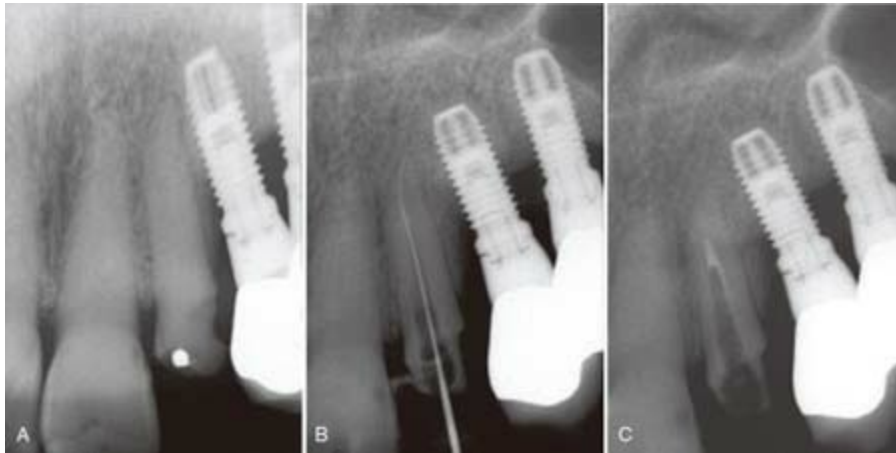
A, Preoperative radiograph tooth #10¹⁵⁸; dystrophic calcification has obliterated the pulp chamber and the coronal half of the canal space. B, A #10 file inserted to estimated working length; the file is actually through a facial perforation of the root at the radicular extent of the ultrasonic excavation. Repeated drying of the canal space using an air syringe forced air through the perforation site and precipitated the emphysema seen in Fig. 20.26, A and B. C, The radicular perforation site was sealed with mineral trioxide aggregate (MTA) before the canal space was obturated. The tooth has remained asymptomatic since the incident.
